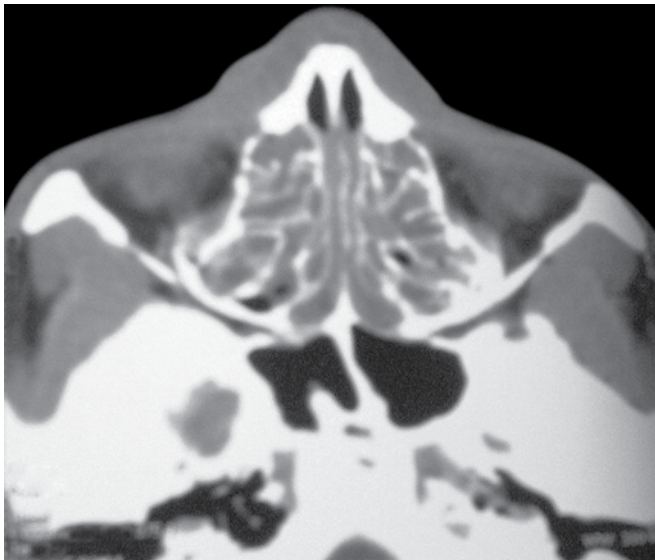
Noncontrast CT scan showing bilateral ethmoidal polyposis
